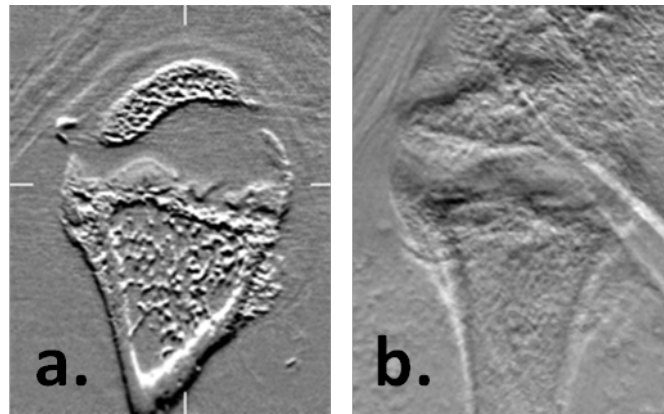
DEI CT sagittal plane image (a) and corresponding DEI projection (b) refraction images.
